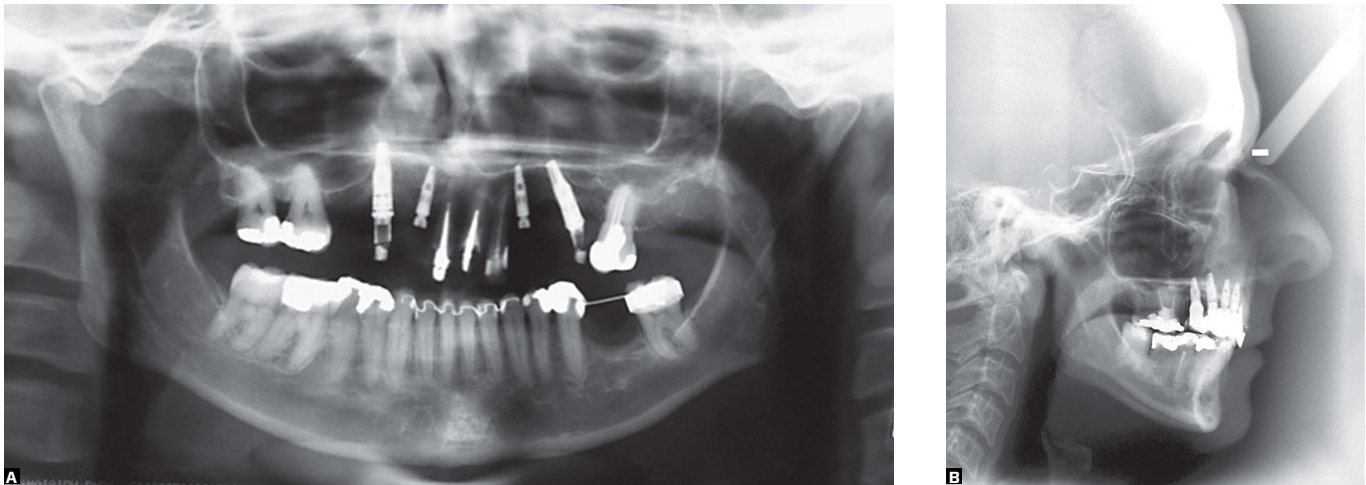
Final radiographs.
